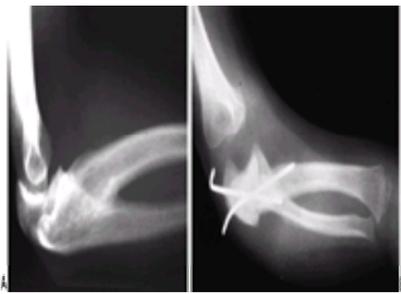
A: Preoperative radiograph of a congenital radioulnar synostosis. There is complete fusion of the proximal radius and ulna, and posterior dislocation of the radial head. The entire ulna is mildly hypoplastic. B: Postoperative radiograph of a derotation corrective osteotomy for this patient. A longitudinal wire is passed down the medullary canal of the ulna across the synostosis site. This Kirschner wire starts from the proximal ulnar apophysis. The osteotomy cut is performed through the synostosis. The transfixing wire is obliquely placed to secure the corrective derotation to a position of 0 to 20 degrees of pronation.
